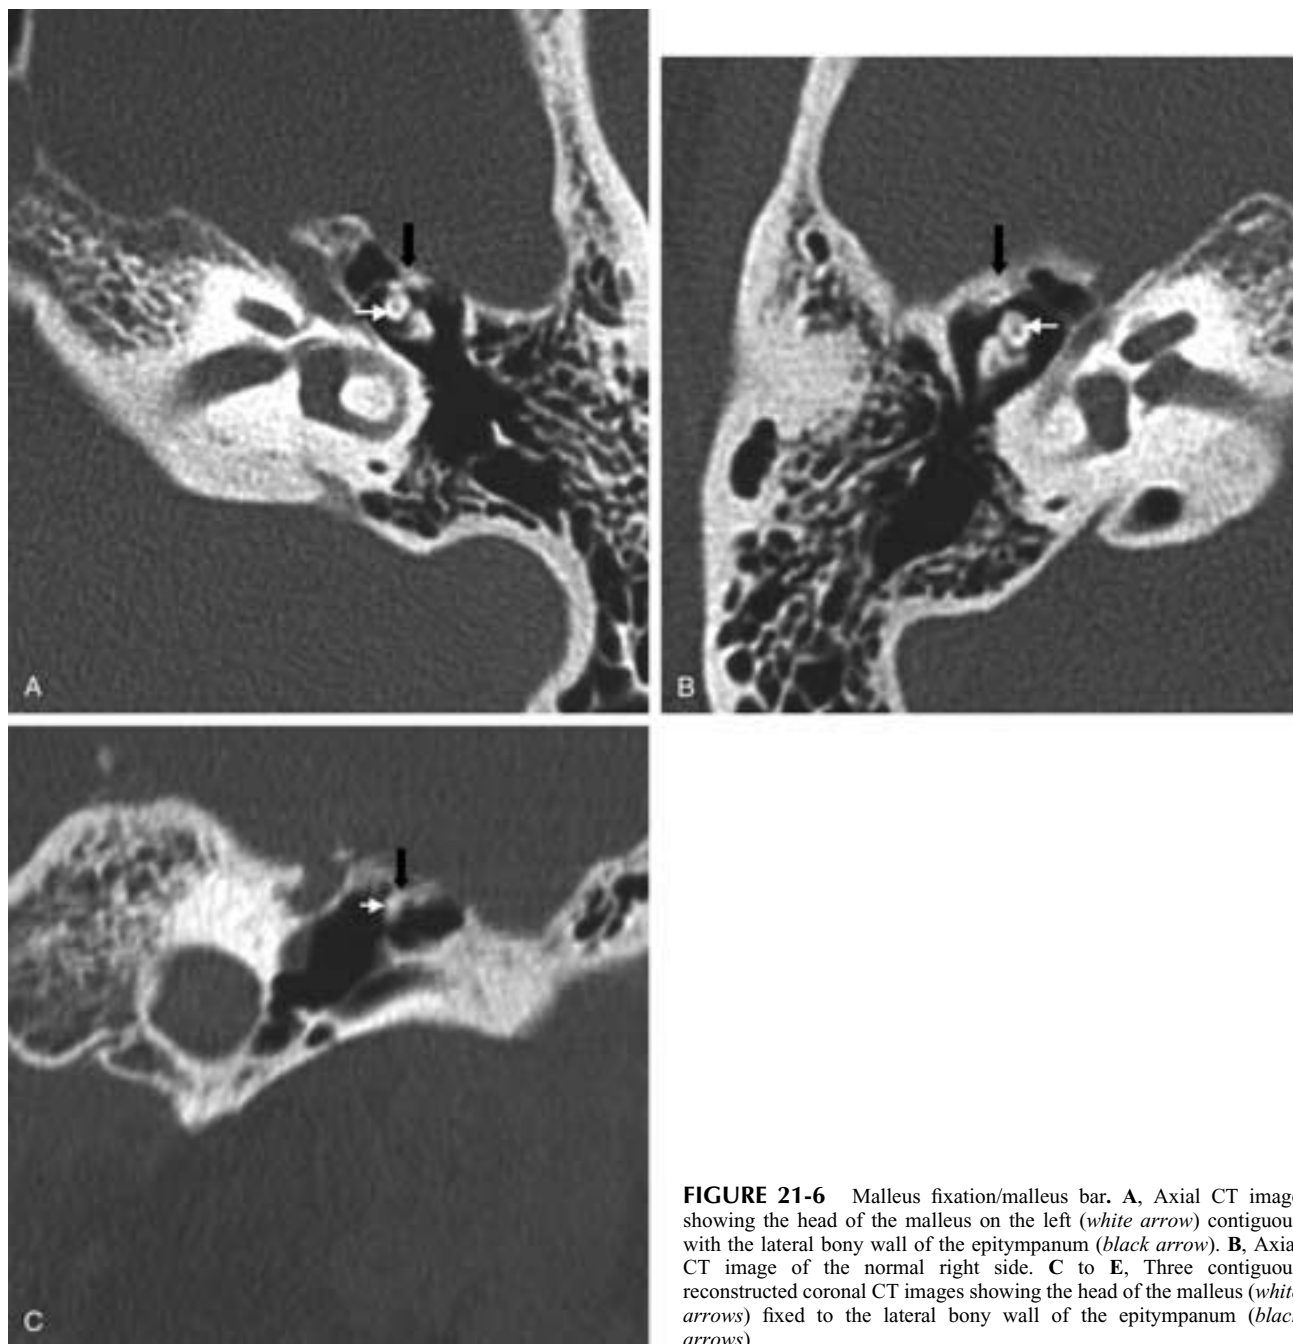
Malleus fixation/malleus bar. A, Axial CT image showing the head of the malleus on the left (white arrow) contiguous with the lateral bony wall of the epitympanum (black arrow). B, Axial CT image of the normal right side. C to E, Three contiguous reconstructed coronal CT images showing the head of the malleus (white arrows) fixed to the lateral bony wall of the epitympanum (black arrows).
